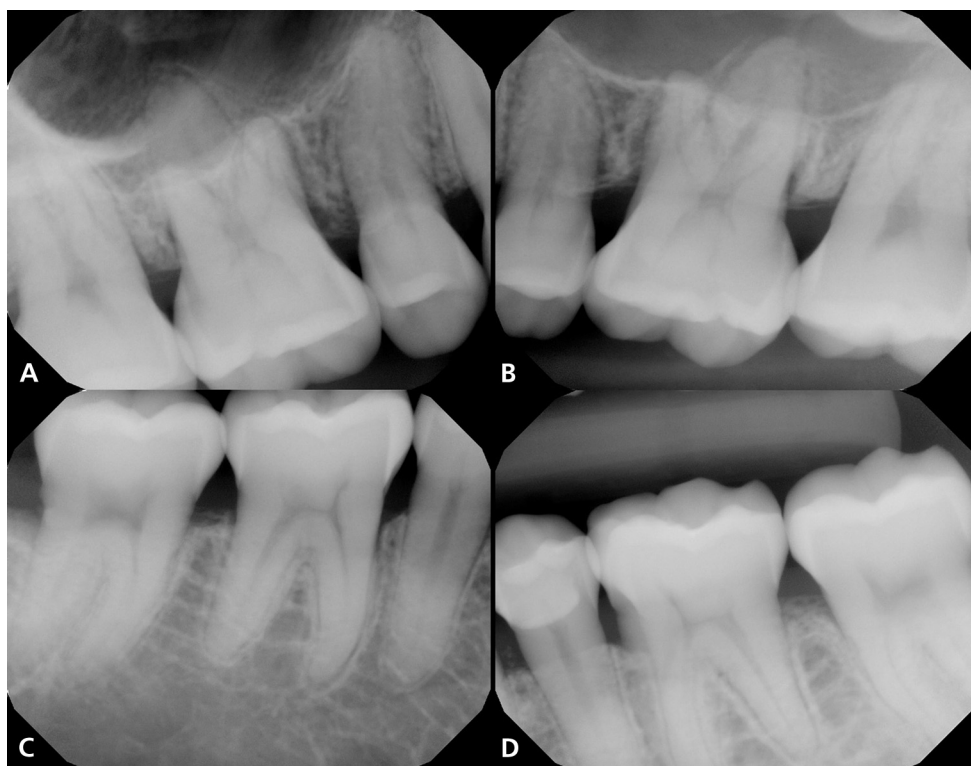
Periapical radiographs of (A) maxillary right, (B) maxillary left, (C) mandibular right, and (D) mandibular left molars demonstrating widening of the periodontal ligaments in each of the first molars.
